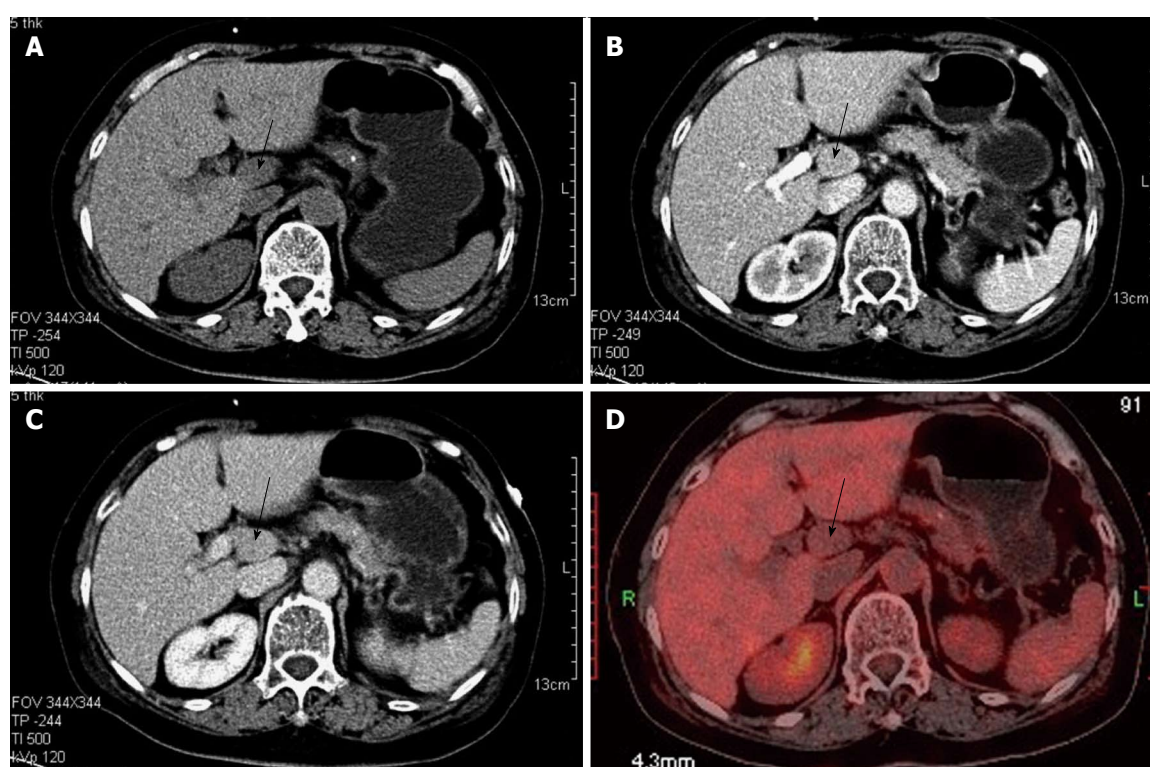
Radiologic findings. A: Plain scanning-phase computed tomography (CT); B: Arterial enhancement-phase CT; C: Equilibrium-phase CT showing the tumor (black arrow) in the retroperitoneum; D: Positron emission tomography showing the tumor in the retroperitoneum with no 18 fluorodeoxyglucose activity.
